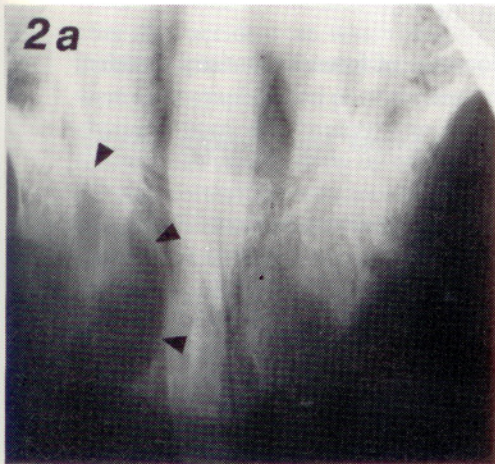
"Antemortem" radiograph. Fig. 2b "Postmortem" radiograph. Three errors were made by the observers in this case. A residual cyst (arrows) is seen on the undistinct "antemortem" radiograph from 1977. The "postmortem" radiograph is taken six years after surgery. The border of the lesion is indicated (arrows).
